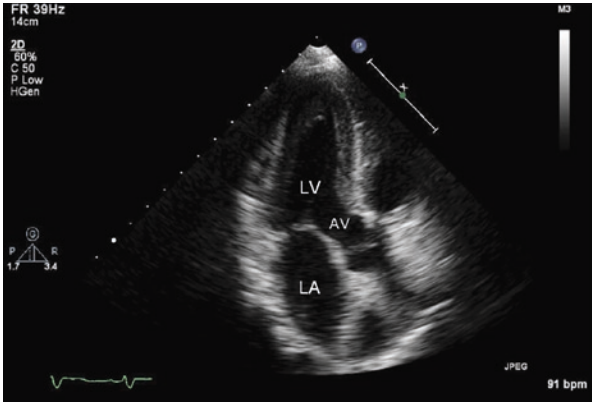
Apical 3 Chamber (3C) or long axis view. The apical 3C view is also known as the apical long axis view. Structures seen in the 3C view are the same as the parasternal long axis view. The 3C view is utilized to assess chamber size and function as well as aortic and mitral valve function
